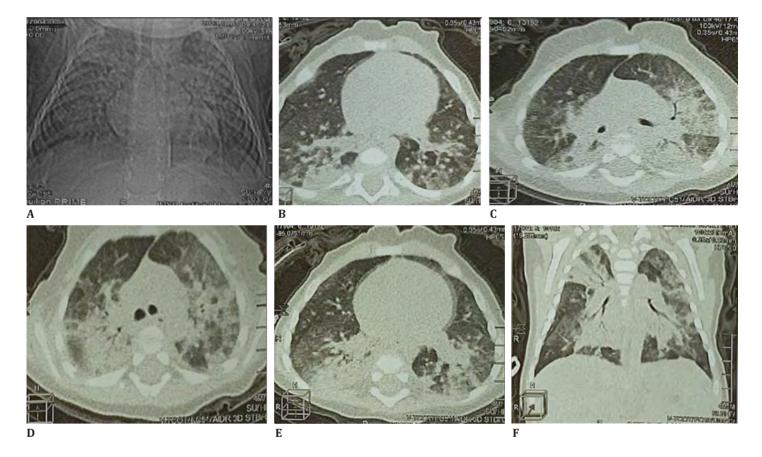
Non-contrast Computed tomography of the chest organs, infant, one month after COVID-19
